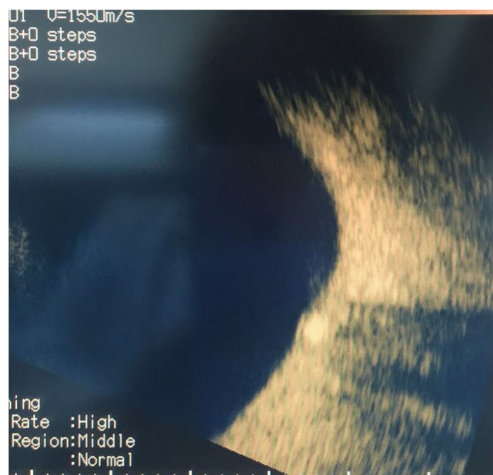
Orbital ultrasonography confirmed diagnoses of pseudopapilledema due to optic disc drusen
